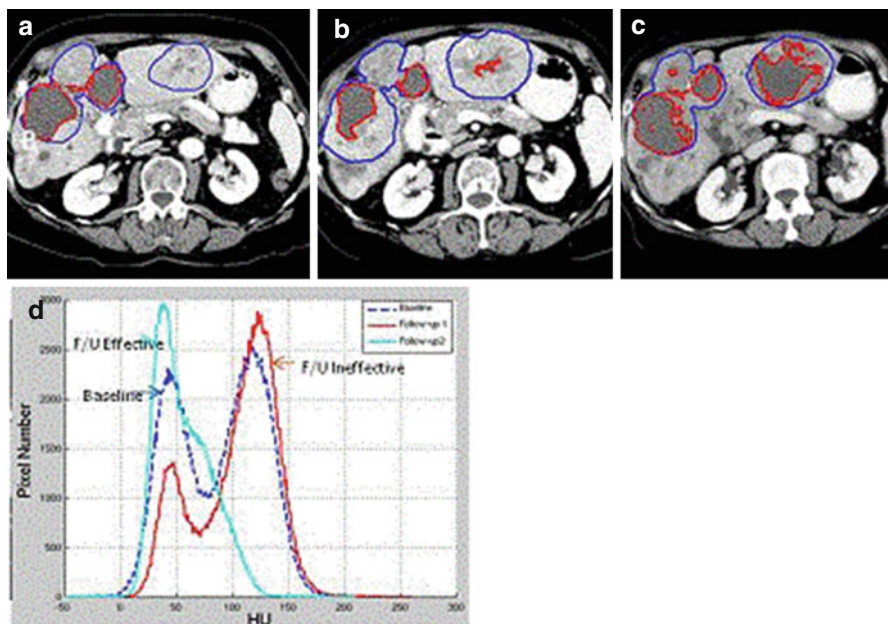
Contrast-enhanced CT scans of an HCC patient enrolled in a growth factor inhibitor trial where target lesion tumors are outlined in *blue* and necrosis is outlined in *red*. (a) At baseline, the ratio of necrosis volume to tumor volume (N/T) was 34 %; (b) at 6 weeks post-therapy there was less necrosis and a decrease in the N/T ratio to 20 %. It was considered to be an ineffective treatment; (c) the patient was then switched to sorafenib, with an increase in the N/T ratio up to 47 %; (d) density histogram of the tumor at baseline (*blue*), at the first follow-up (*red*), and at the final time point (*turquoise*)
